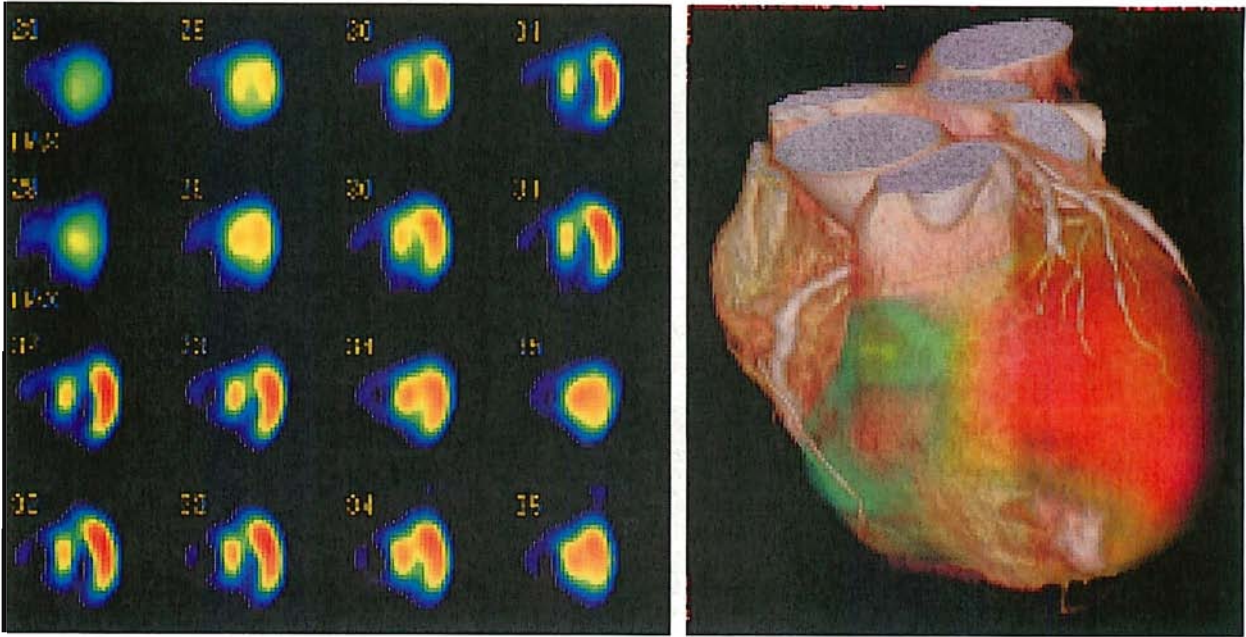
An 80-year-old man suspected old myocardial infarction with angina. A. Myocardial perfusion SPECT (horizontal long-axis image) shows a perfusion defect in the anterior and septal wall with partial redistribution (small arrow). B, C. Volume-rendering fused images demonstrated a myocardial perfusion defect (B, small arrow) distal to the occluded coronary artery (seg.7, arrow) and a stenosed coronary artery (seg.9, small arrow). D. Conventional angiography showed occlusion of seg.7 (arrow) and 90% stenosis of seg.9 (small arrow).
